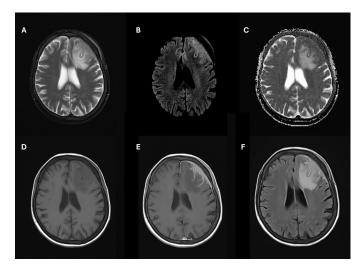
Magnetic resonance imaging findings at the time of diagnosis. On T2-weighted (A) and FLAIR (F) images, vasogenic edema adjacent to the lesion in the left frontal lobe is observed as a hyperintense signal. Diffusion-weighted imaging (B) and apparent diffusion coefficient map (C) demonstrate restricted diffusion within the lesion. The lesion appears hypointense on non-contrast T1-weighted image (D), while prominent contrast enhancement is seen on contrast-enhanced T1-weighted image (E).
